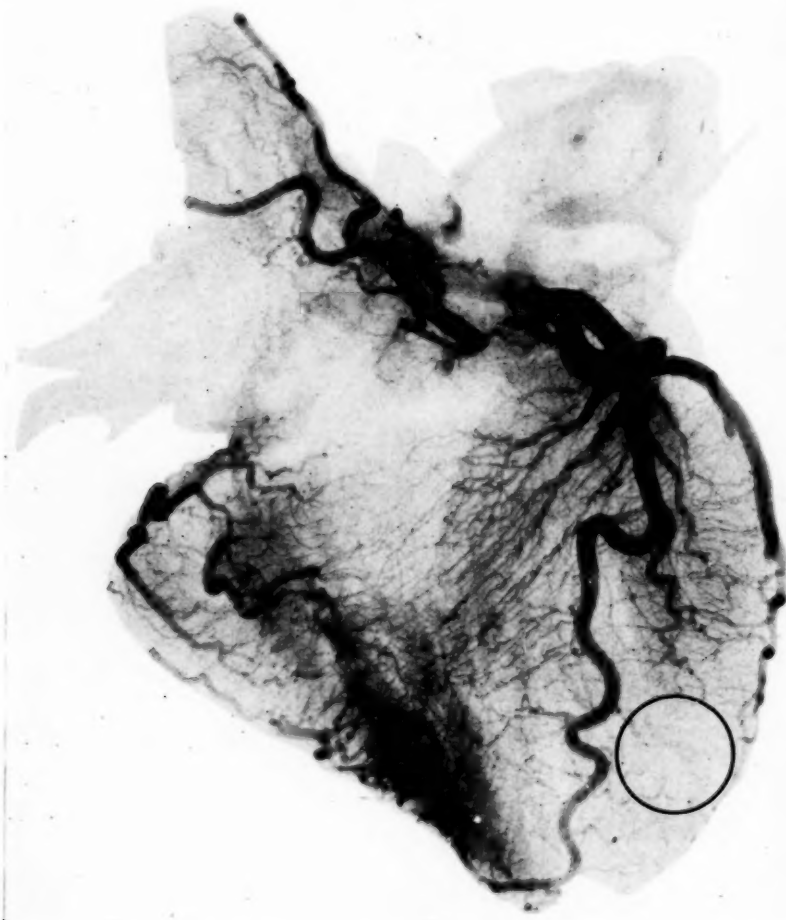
X-ray film of the heart showing the decrease in number and size of capillaries at the site of the contusion near the apex of the left ventricle. Coronary arteries were injected with a barium paste.
